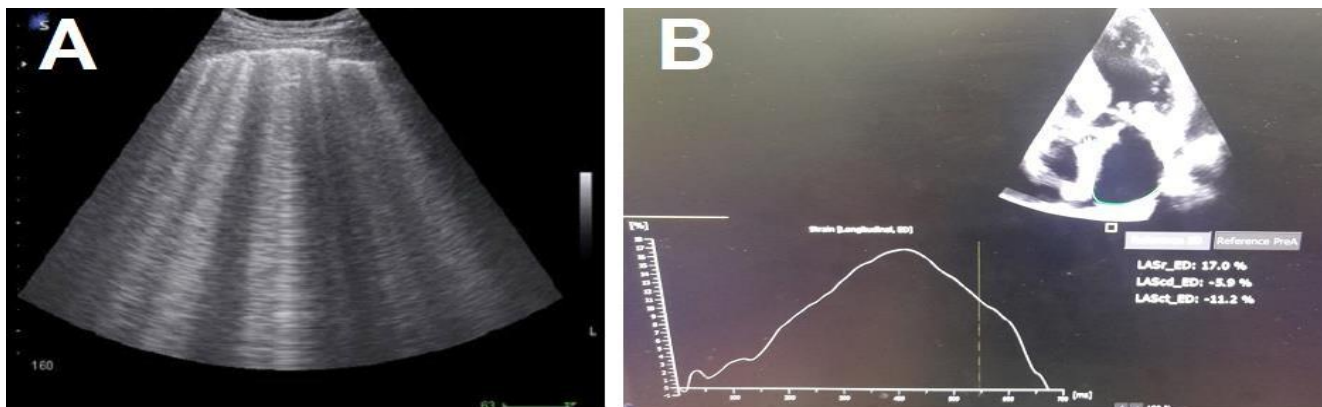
A) Ultrasound evaluation of lung shows confluent B-lines of longitudinal white lines appearance and B) determination of left atrial reservoir strain in patients with HFpEF.
